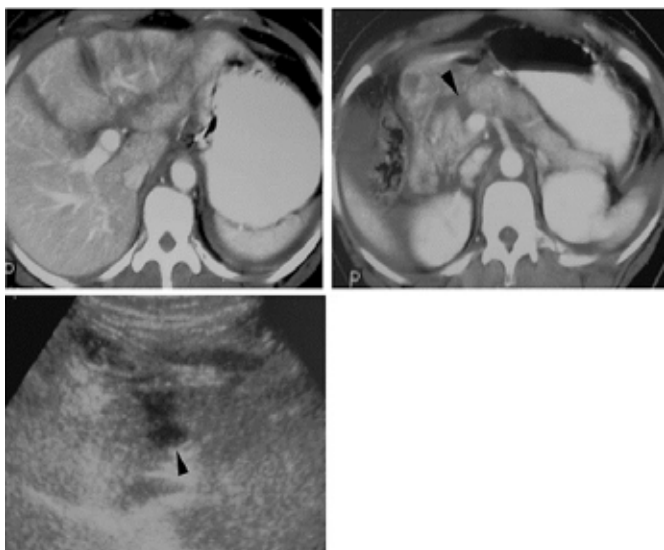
Pancreatic trauma in adults. Images "a" and "b" are from contrast-enhanced computed tomography. Image "c" is from ultrasound<sup>9</sup>.
